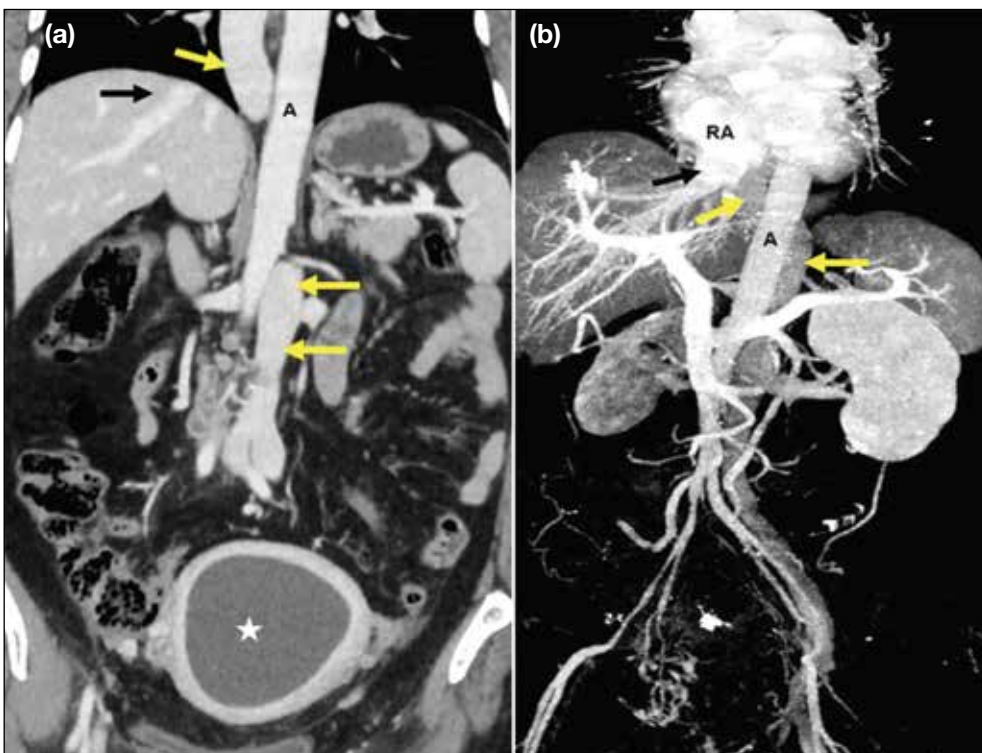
(a) Coronal contrast-enhanced computed tomography and (b) posterior maximum intensity projection images of a patient with cervical carcinoma and pyometra (star in [a]) show a left inferior vena cava crossing the midline posterior to the aorta (A), continuing as the azygos-superior vena cava pathway (yellow arrows). Hepatic veins (black arrows) drain separately into the right atrium (RA).
